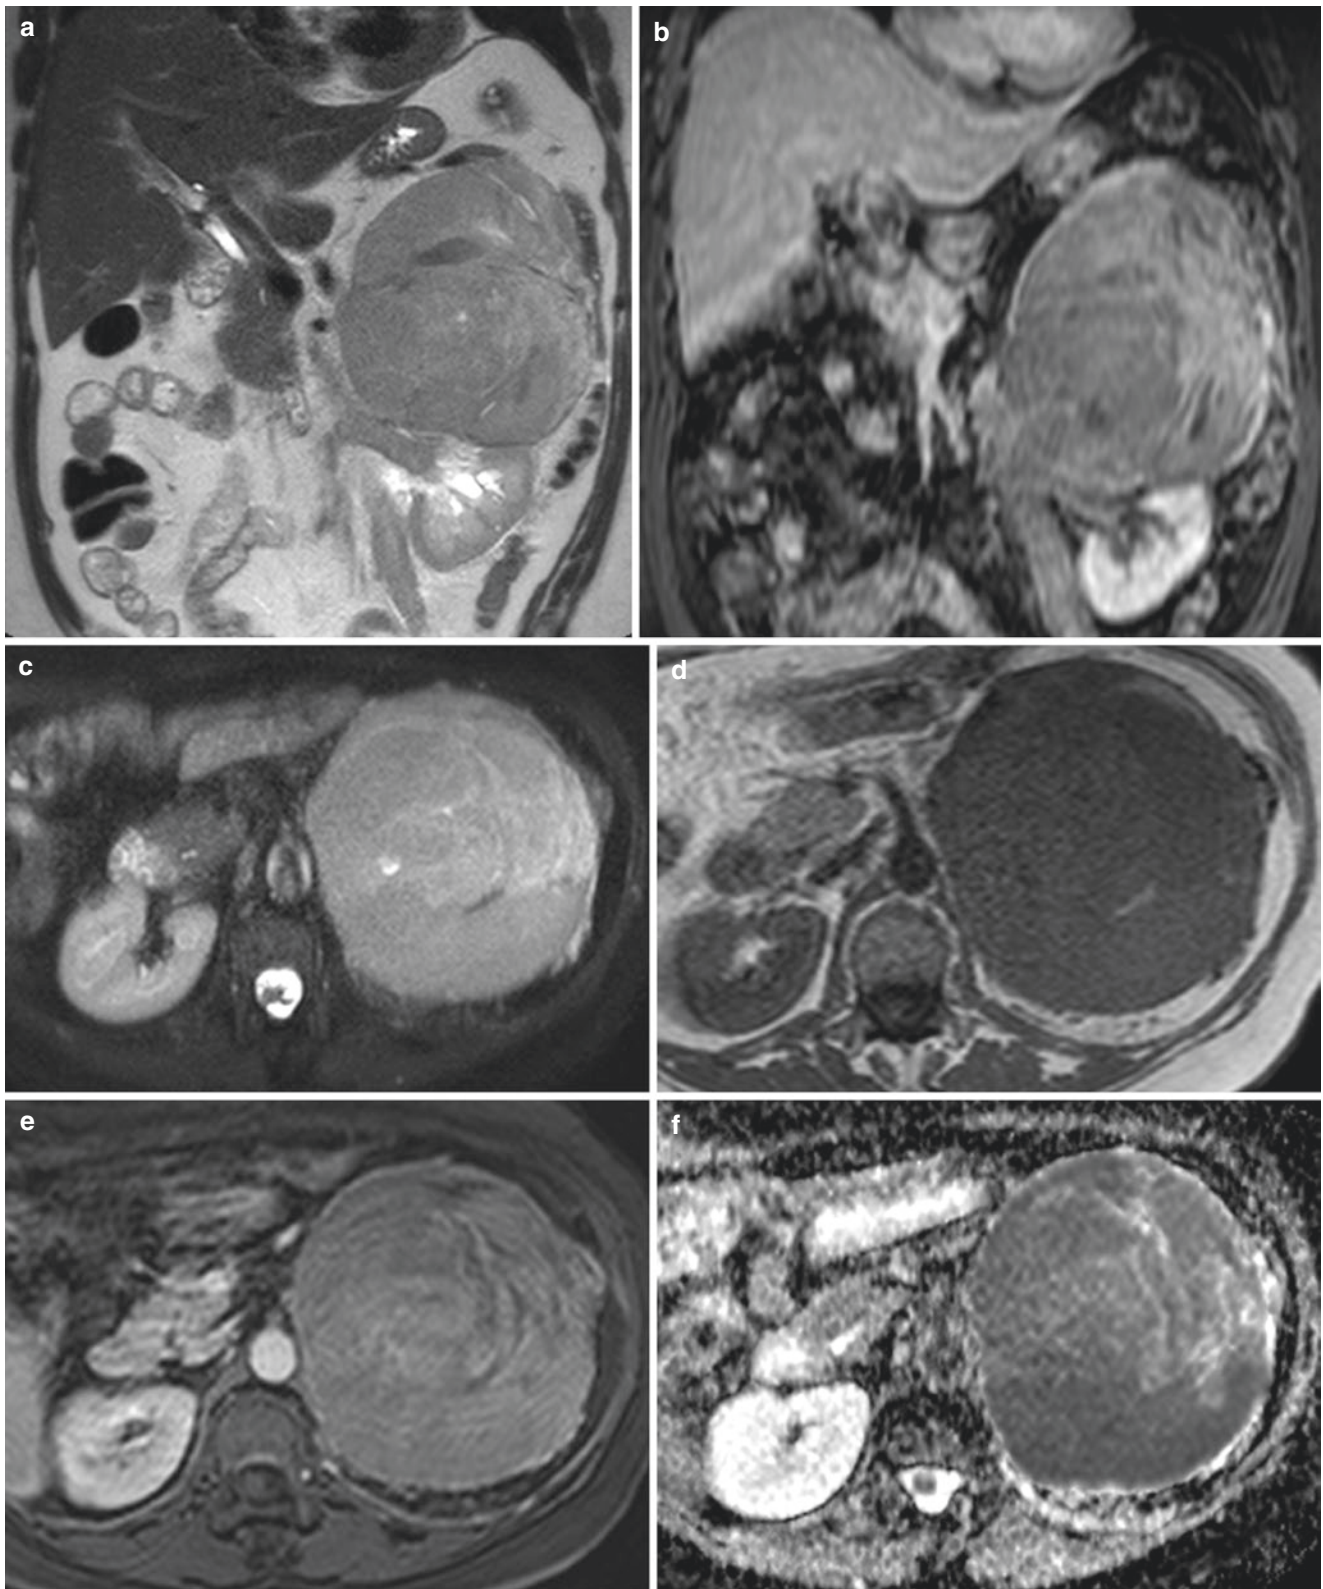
Adrenocortical carcinoma. Coronal (a) and axial (c) T2-weighted and post-gadolinium T1-weighted (b) with axial pre-(d) and post-gadolinium (e) T1-weighted MR images, and ADC map (f). Large and heterogeneous left adrenal mass with restricted diffusion (low-signal intensity on f), and heterogeneous enhancement on post-gadolinium images. Left kidney is compressed and dislocated inferiorly by the tumor
